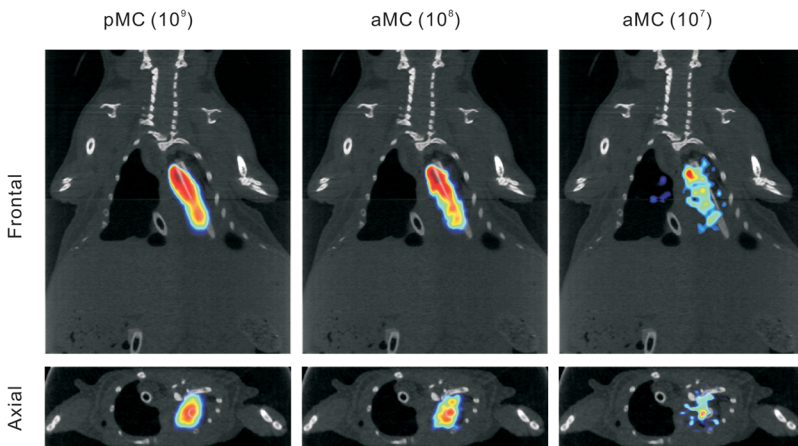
The 25% rising gate reconstruction using (a) the pMC method with 10^9 photons, (b) the aMC method with 10^8 photons, and (c) the aMC method with 10^7 photons. The optical reconstructions are performed without any anatomical priors besides the external body boundaries. The optical reconstructions are overlaid on the Micro CT image for visualization/validation only.
